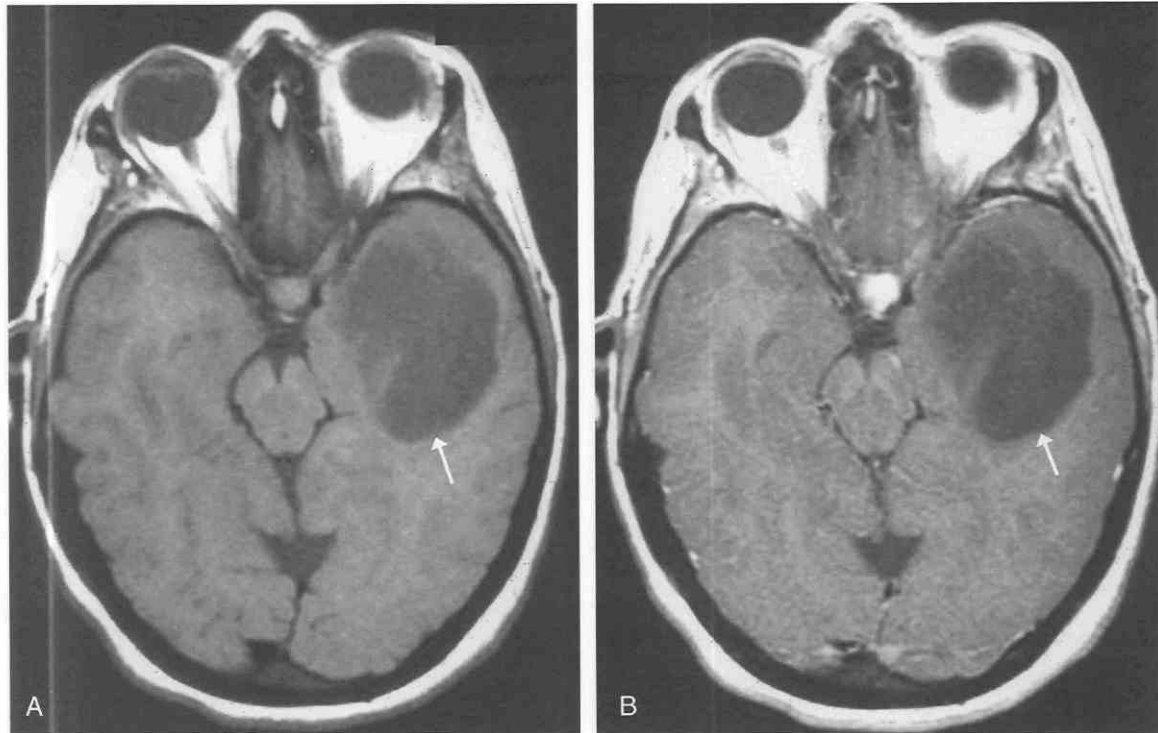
Low grade astrocytoma of the temporal lobe. Axial T1-weighted MR images prior to (A) and following (B) intravenous administration of gadolinium. A mostly ill defined homogeneously hypointense mass expands the left anterior temporal lobe (arrow). There is no contrast enhancement and no surrounding edema. Note medial displacement of the medial margin (uncus and parahippocampal gyrus) of the left temporal lobe indicating early transtentorial herniation with compression of the left ambient cistern and the anterolateral aspect of the left cerebral peduncle.
